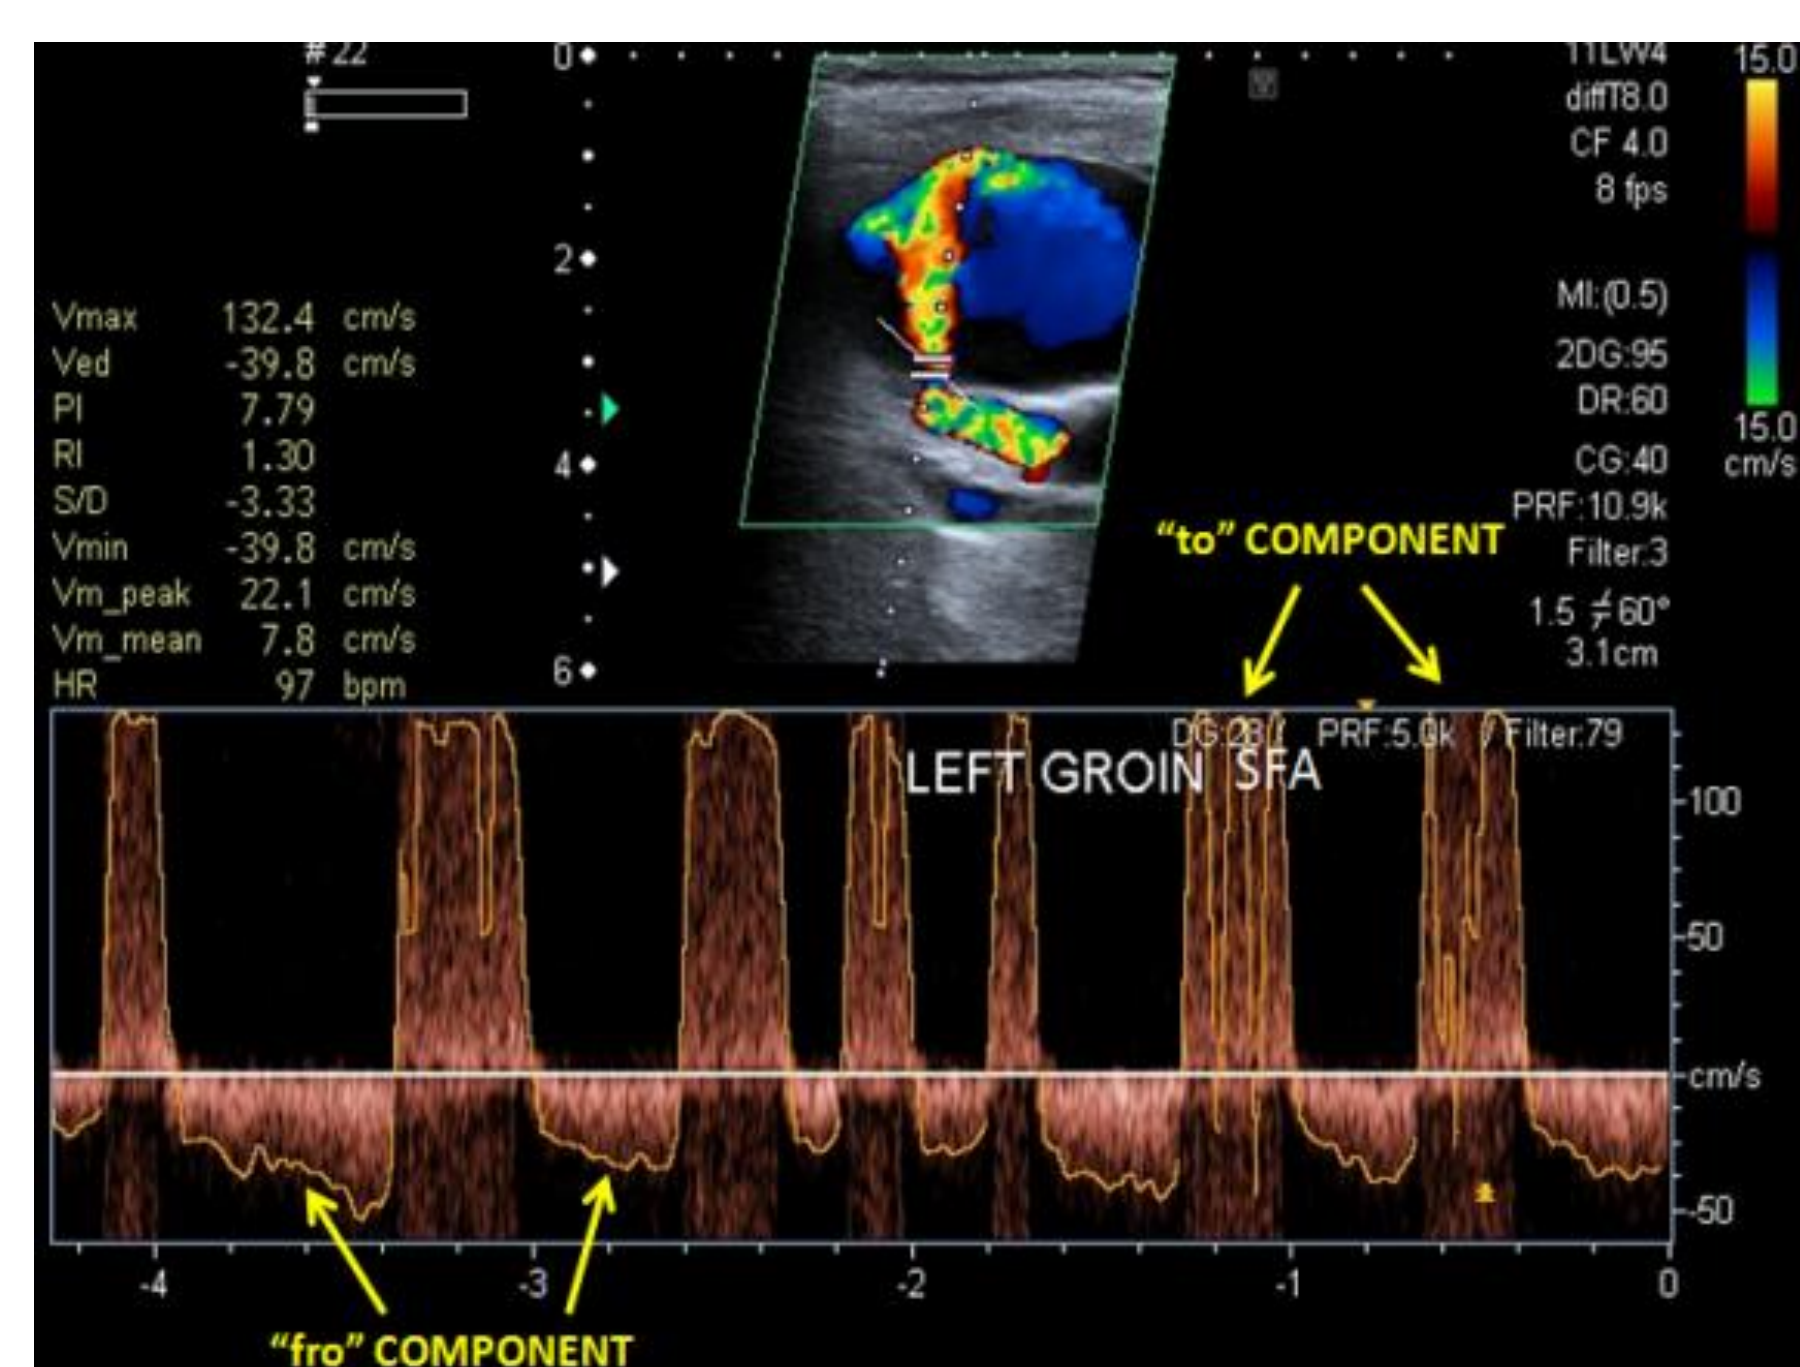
LS spectral Doppler image demonstrates a biphasic "to-and-fro" waveform in the communicating neck between the SFA and PSA chamber. The "to" component represents blood entering the chamber during systole, while the "fro" component represents blood exiting during diastole (Mahmoud et al., 2015).
